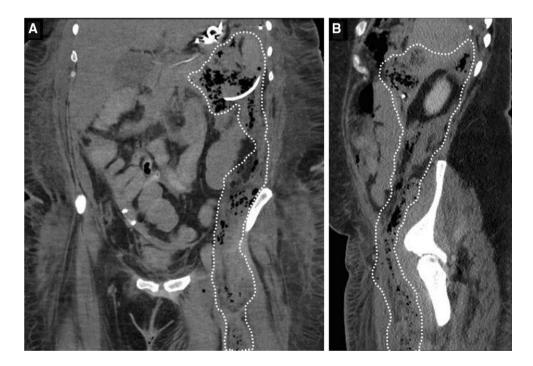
Case #4. a Coronal CT image of left-sided walled-off necrosis (WON; dotted line). b Sagittal CT image of WON. Note extension of WON into left thigh
